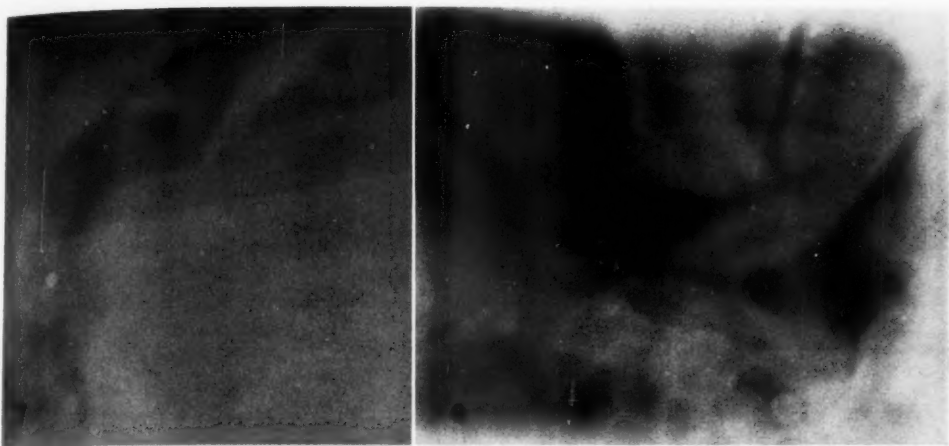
Cobalt-60 radiograph to verify positioning for treatment of the pituitary tumor shown in Figure 3, the co-ordinates having been determined by pretreatment localization filming. The sella turcica is partly outlined by the air in the sphenoid sinus. Ear plug of the head-holder in the external auditory canal is visible.
